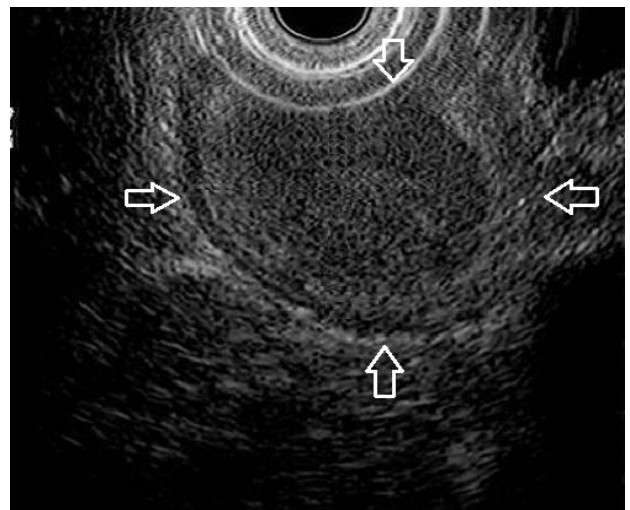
Endoscopic ultrasound using a radial probe showing the tumor in the duodenal submucosa extending down to the muscularis propria.
